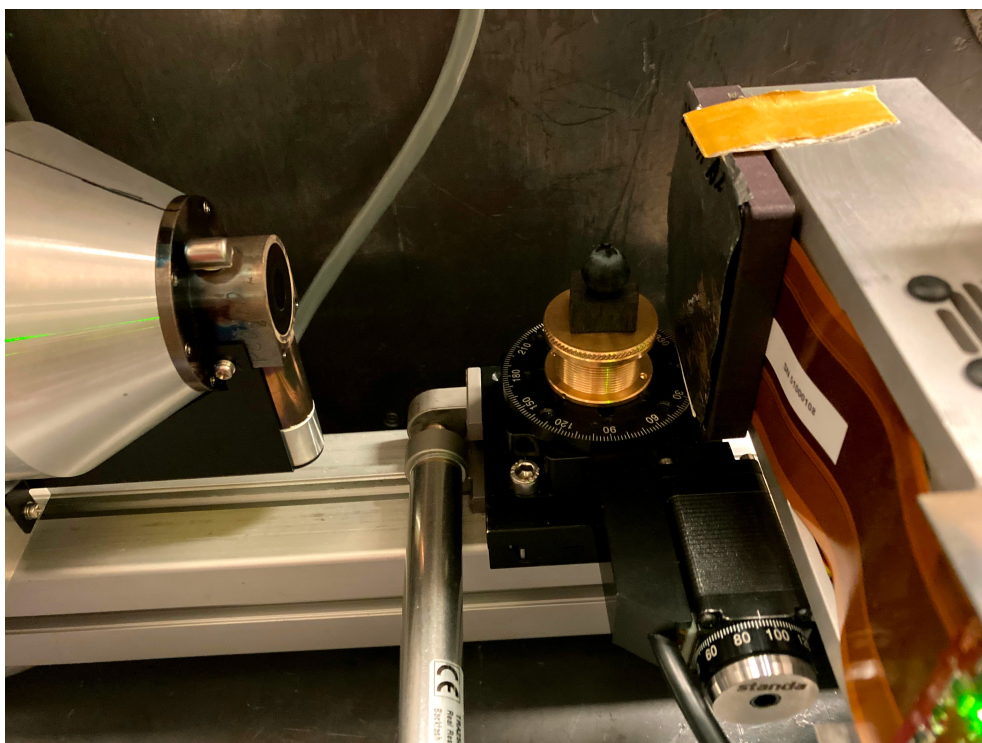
An image of the experimental setup for 2D and CT imaging of a blueberry, which is on the manually controlled brass stage. This is on the black rotation stage with white letters indicating the current angle. There is a filter on the detector.
